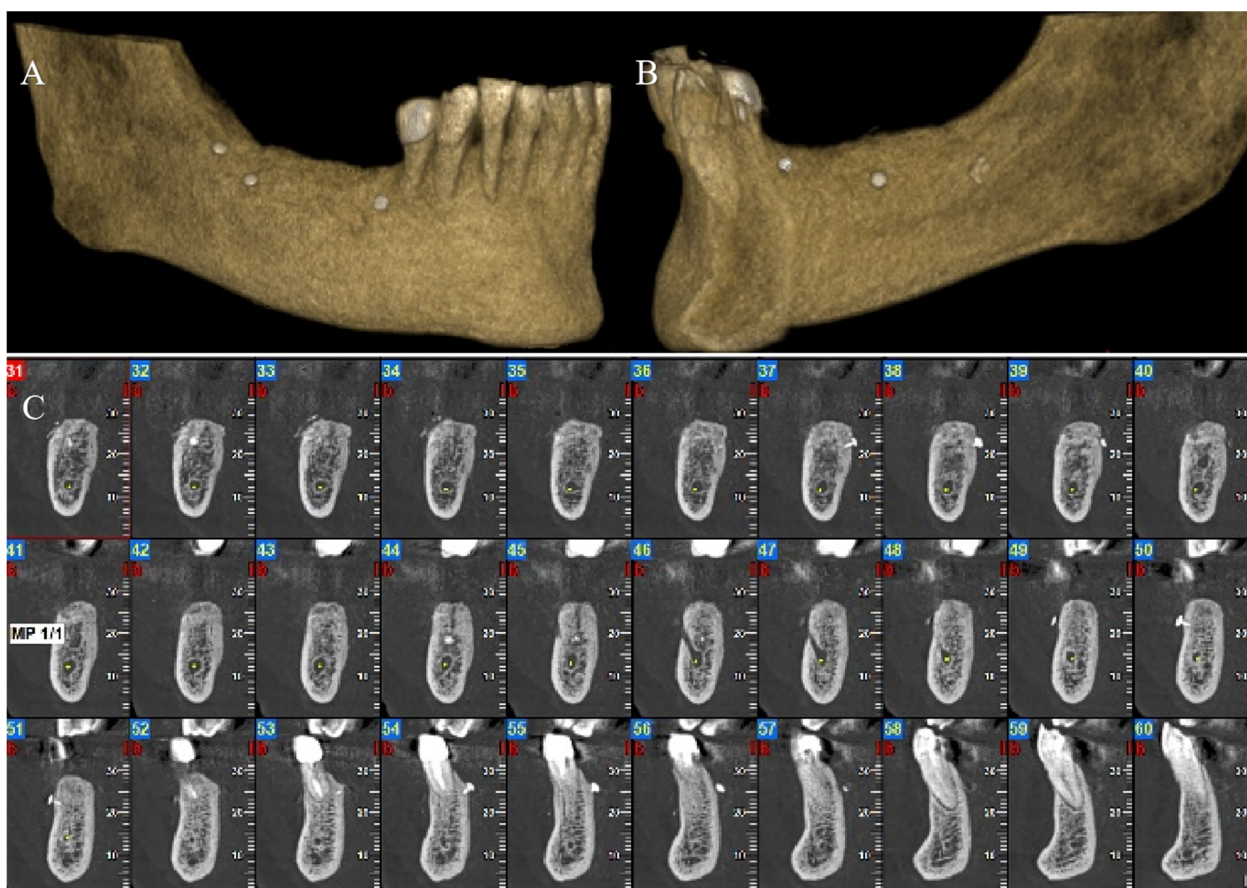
Twelve months after GBR a cone beam computed tomography was repeated: the tacks stabilizing the collagen membrane on the buccal (A) and lingual (B) side are still present. The scans show the resolution of the vertical bone defect (C).
